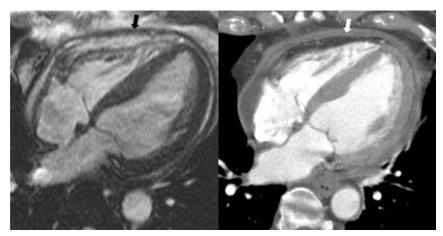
Inflammation-related pericardial surface enhancement on contrast-enhanced CT (four chamber). Compared with cine (SSFP) CMR (*left*; Video 1; available at www.onlinejase.com), which shows nonspecific overall thickening of the pericardium (*black arrow*), corresponding post–iodinated agent CT (*right*; Video 2; available at www.onlinejase.com) reveals enhancement of both outer parietal and inner visceral layers of the pericardium due to inflammation (*white arrow*) with interposed mild effusion.
